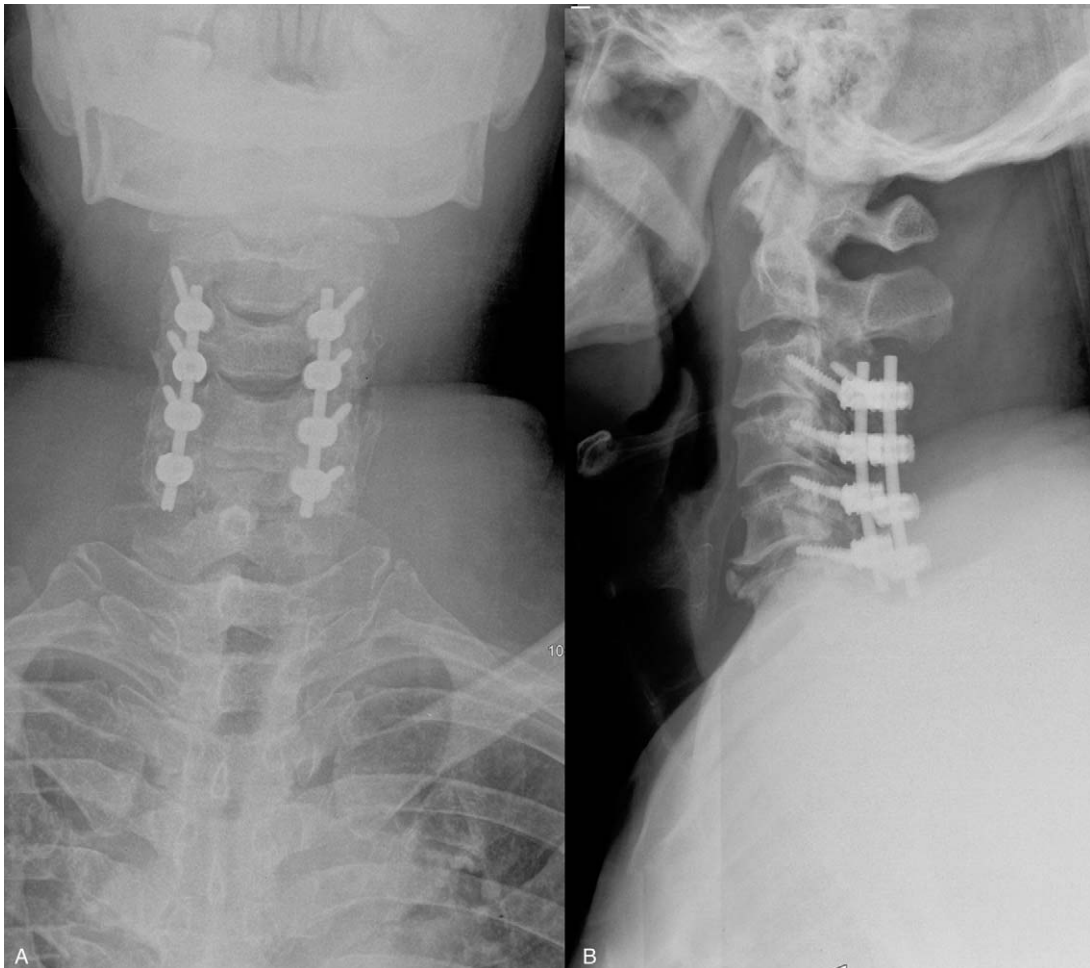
Postoperative radiography of the neck shows the surgery of C3–6 decompression with laminoplasty and internal fixation (A, anteroposterior view; B, lateral view).
